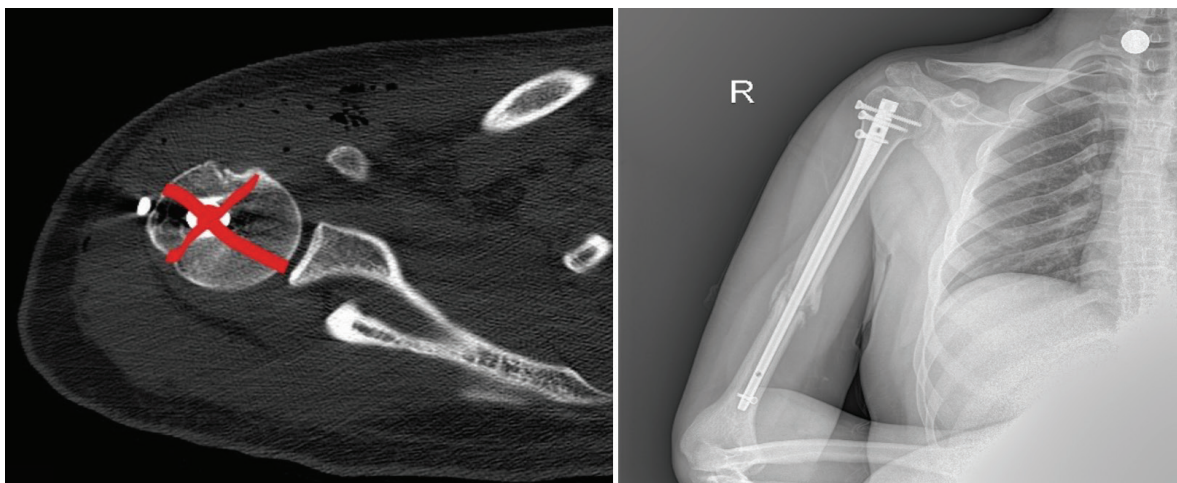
Axial section of the computed tomography of a patient in the postoperative period showing that the nail is at the appropriate insertion point, marked with an “X” (left). The postoperative X-ray of the same patient, where the varus was measured as 0.63° (right)
